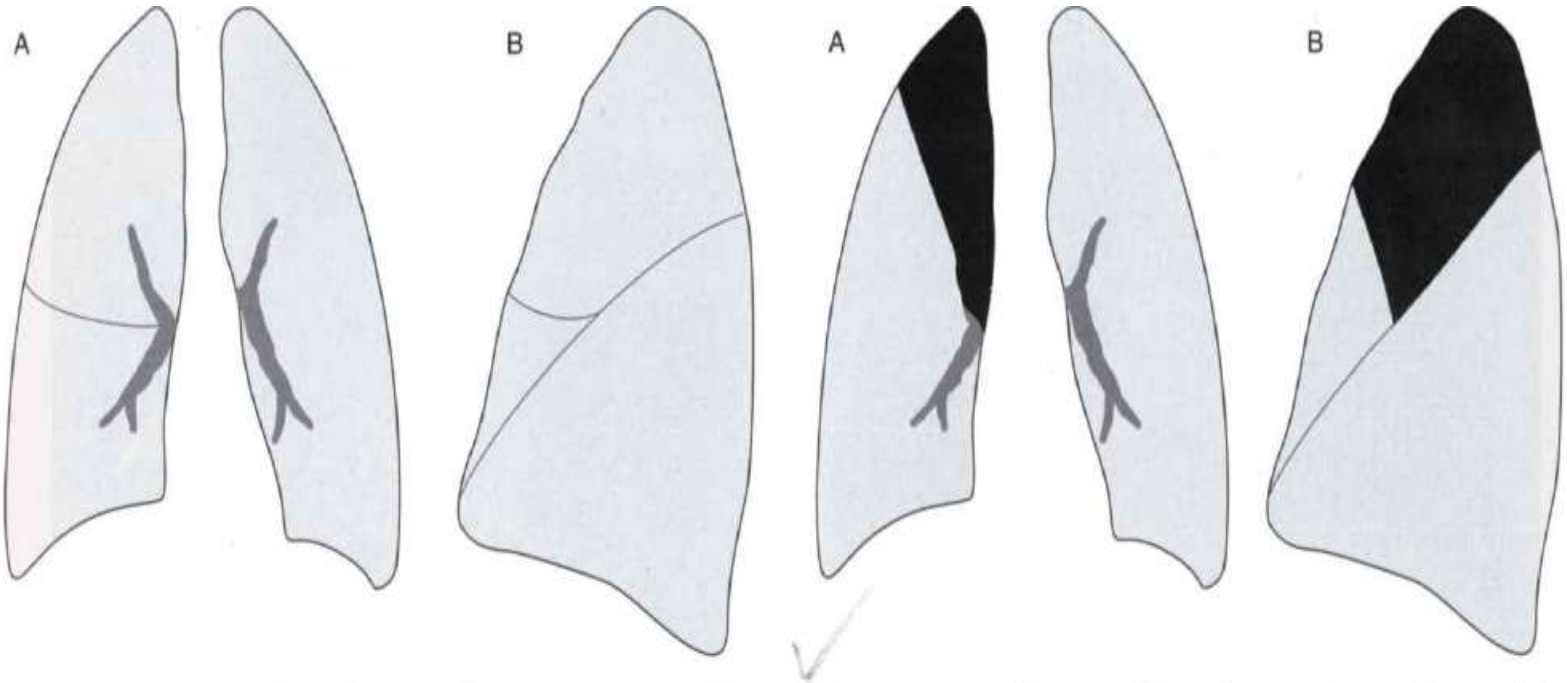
Normal lung volumes and fissures. Frontal (A) and lateral (B) views of the chest show normal positions of the minor (horizontal, right-sided) and major (oblique, bilateral) fissures. The major fissures are often superimposed on the lateral chest radiograph and are usually not seen on the frontal view.
